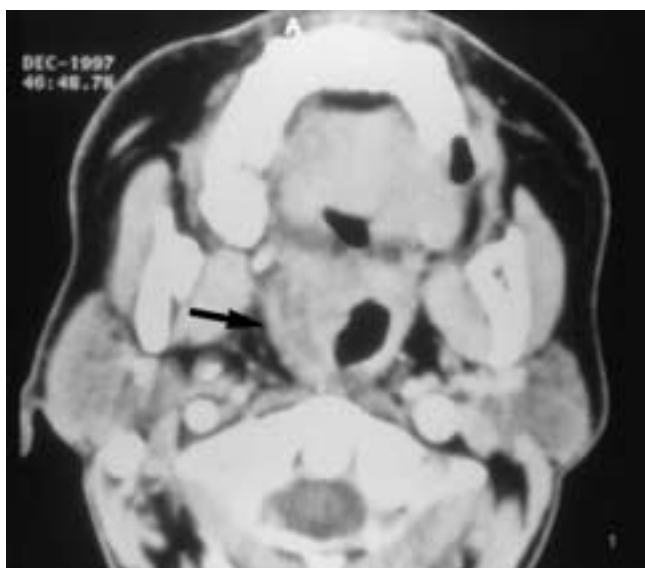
Axial contrast-enhanced CT scan shows diffuse thickening of the right tonsil consistent with inflammation (*arrow*). There is no evidence of a tonsillar or peritonsillar abscess.
